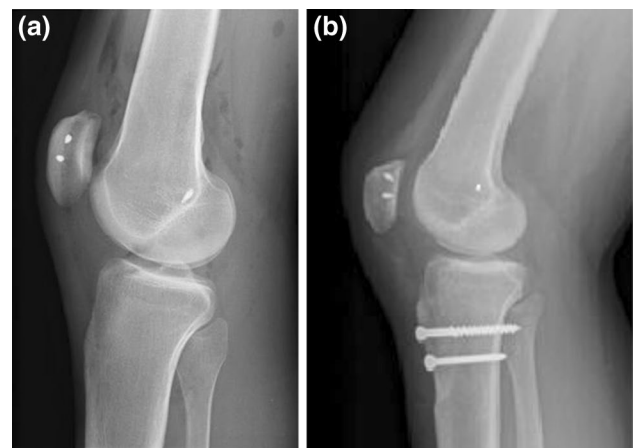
Postoperative radiograph after MPFL reconstruction (a) and associated with tuberosity transfer (b)
